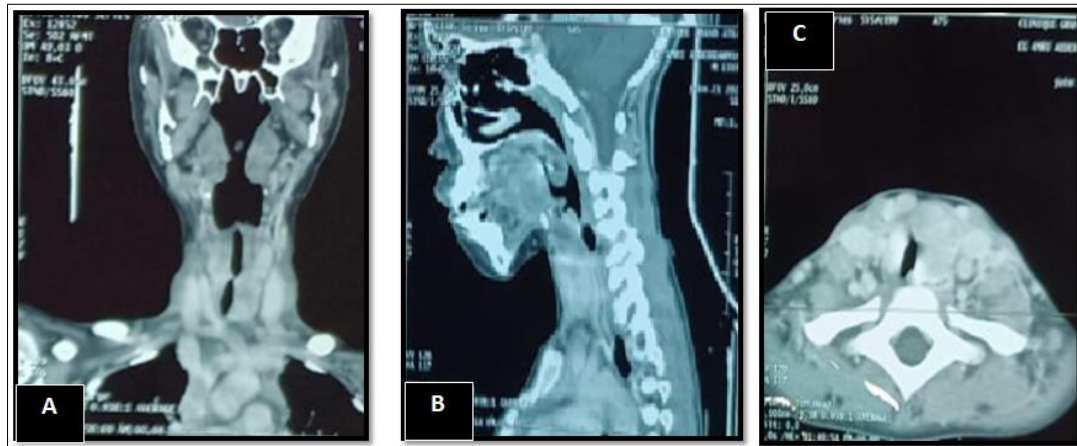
Cervical CT scan with frontal (A), sagittal (B) and axial (C) slices showing a goitre on thyroiditis with reduction of the tracheal lumen and probable subglottic oedema with jugular carotid and submandibular lymph nodes
